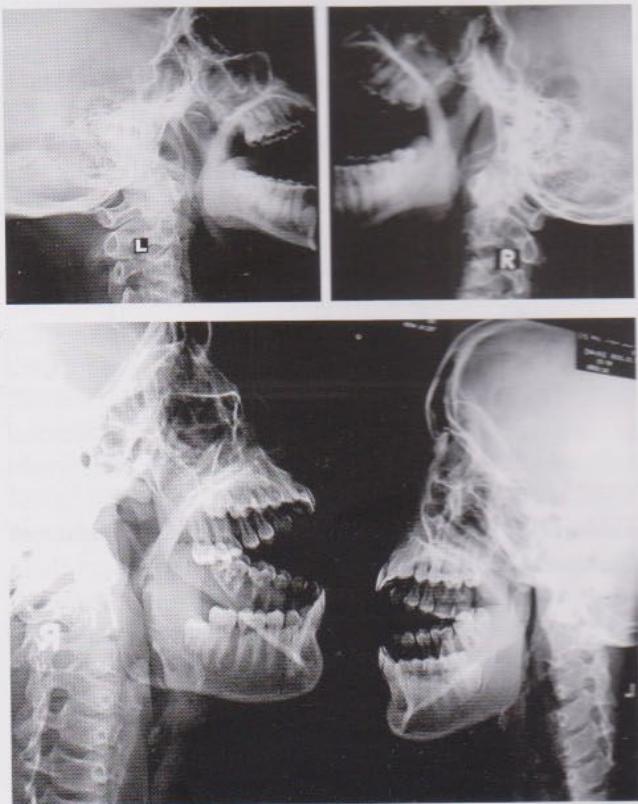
X-ray Styloid process of Skull (Lateral & Panoramic views) showing elongated SP ranging from 3 cms to 7 cms.
